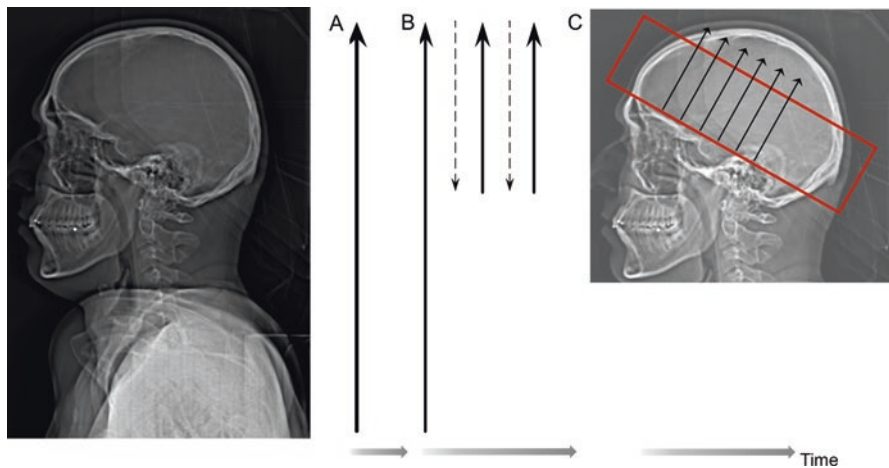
Comparison of CTA and CTP acquisitions. (a) Conventional single-phase CTA is acquired from the aortic arch to the vertex. (b) Multiphase CTA is composed of a 3-phase shuttle-mode angiography. The first phase is similar to the conventional single-phase CTA, followed by two additional phases only from skull base to vertex, each separated by 4 s of repositioning and 3.4 s of scanning time. (c) This is an example of CTP using a single-slab acquisition, with approximately 8 cm of coverage. The inferior border of the slab should be positioned parallel to and just above the orbital roof. Images are acquired parallel to the longitudinal plane of the slab. Optimal time of acquisition may be dependent on the venous output function (VOF), and typically ranges between 45 and 90 s
